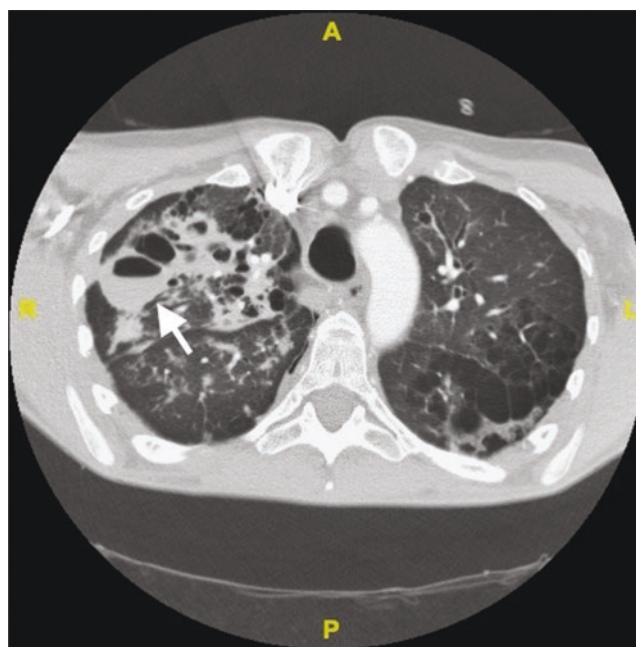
CT scan showing bronchiectasis, scarring, and cystic changes (posterior left lung). Other findings included bilateral patchy ground-glass opacities and a fluid-filled bulla in the right upper lobe concerning for a cavitary lung lesion (arrow)
